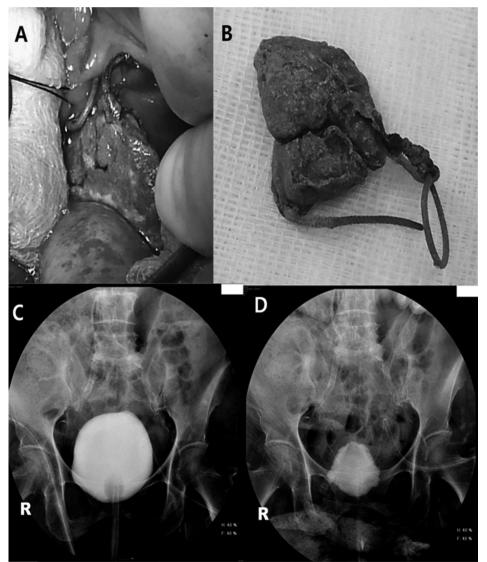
The bladder stone was formed in the middle of the suture material through the right posterior wall of the bladder during the operation (A). The bladder stone, including suture material, was removed by resection of the suture material (B). Three-dimensional computerized tomography (3D-CT) of the pelvis without contrast enhancement after removal (C).
